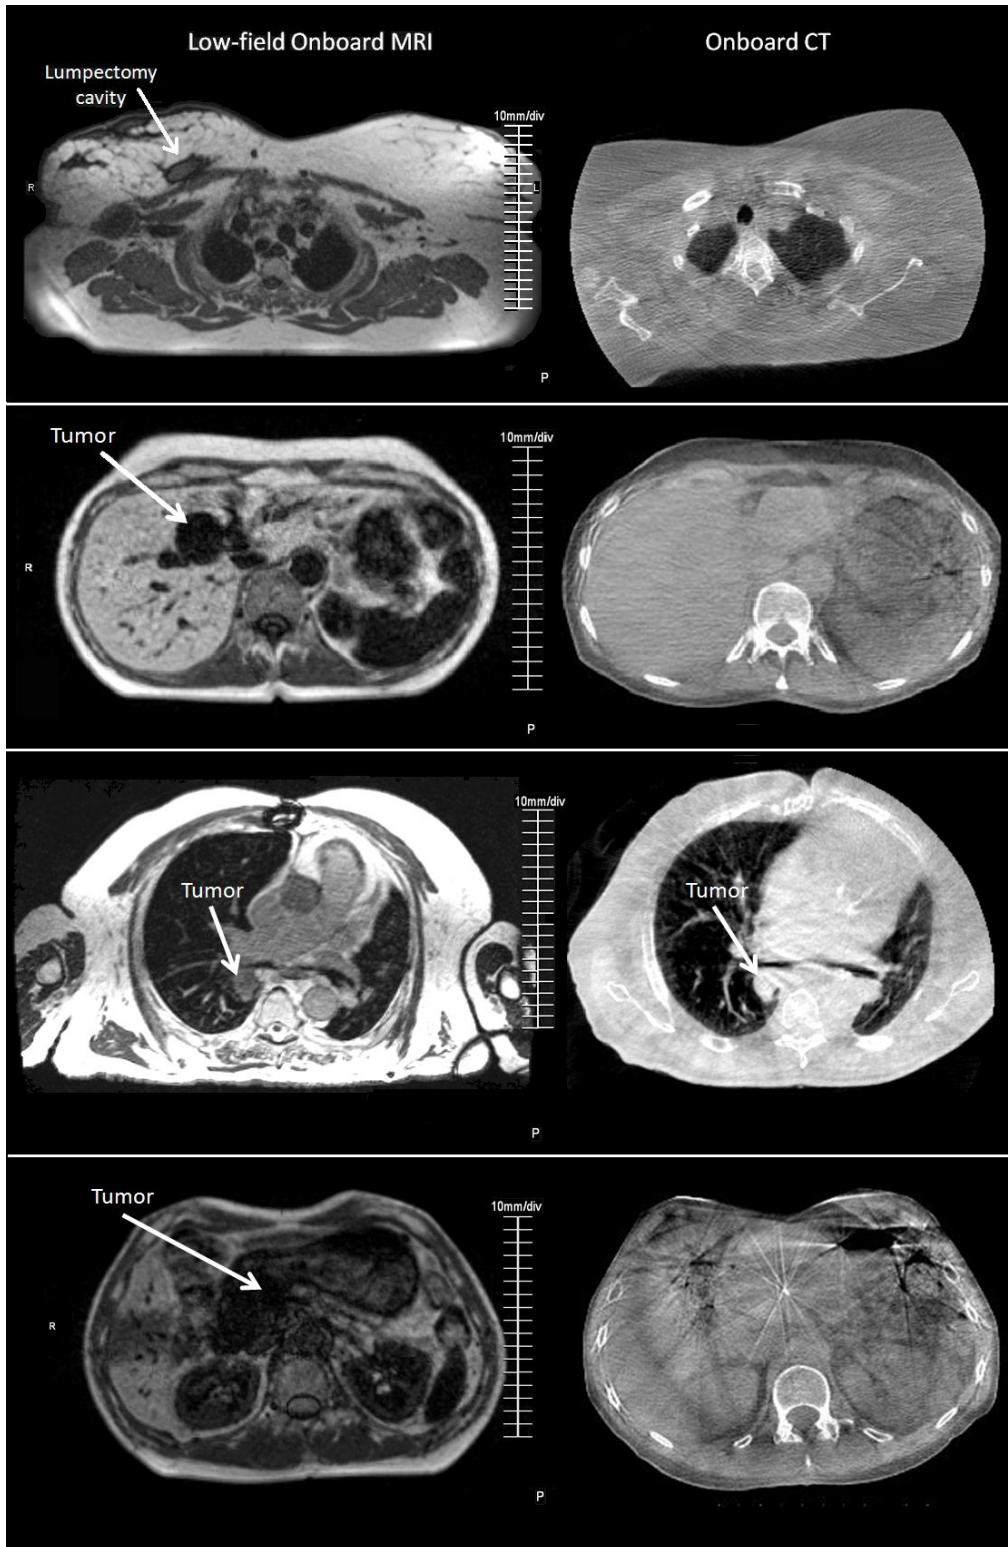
Examples of OB-MRI/OB-CT image set pairs for four targets: lumpectomy cavity, liver tumor, lung tumor, pancreas tumor (from top to bottom).
